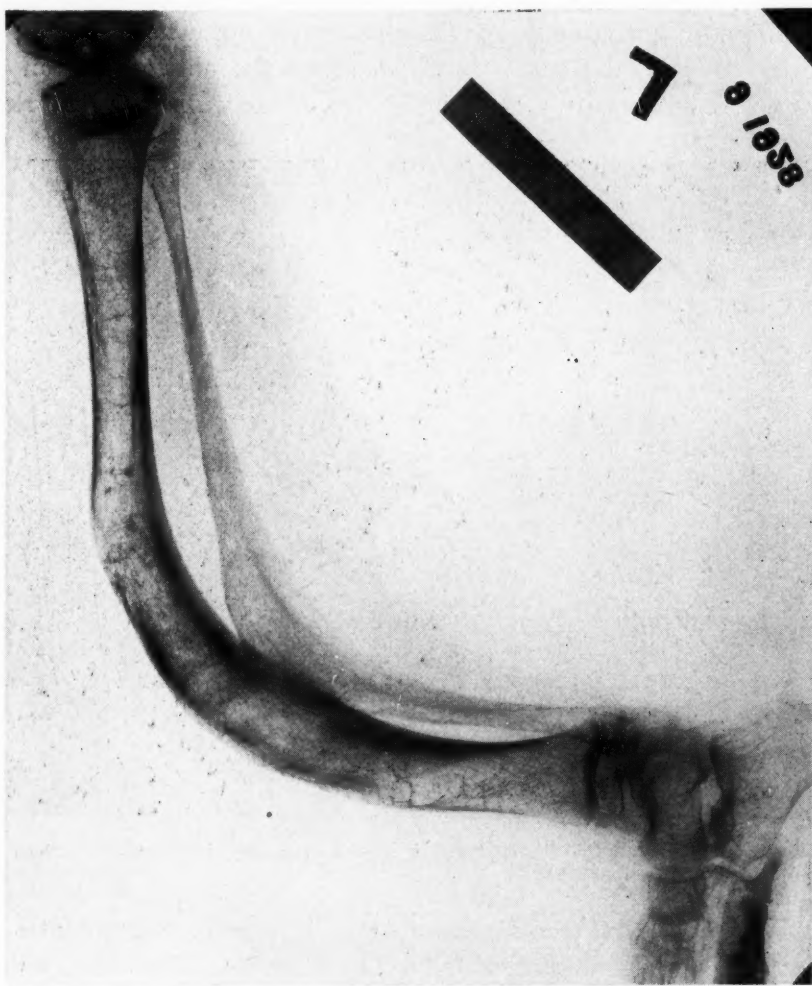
X-ray of leg of patient shown in Fig. 1.
